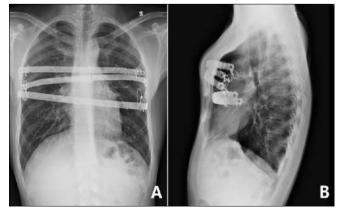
Postoperative X-ray examination. The position of the steel bars and the shape of the thorax were showed. A. Posterioanterior radiograph; B. lateral radiograph
